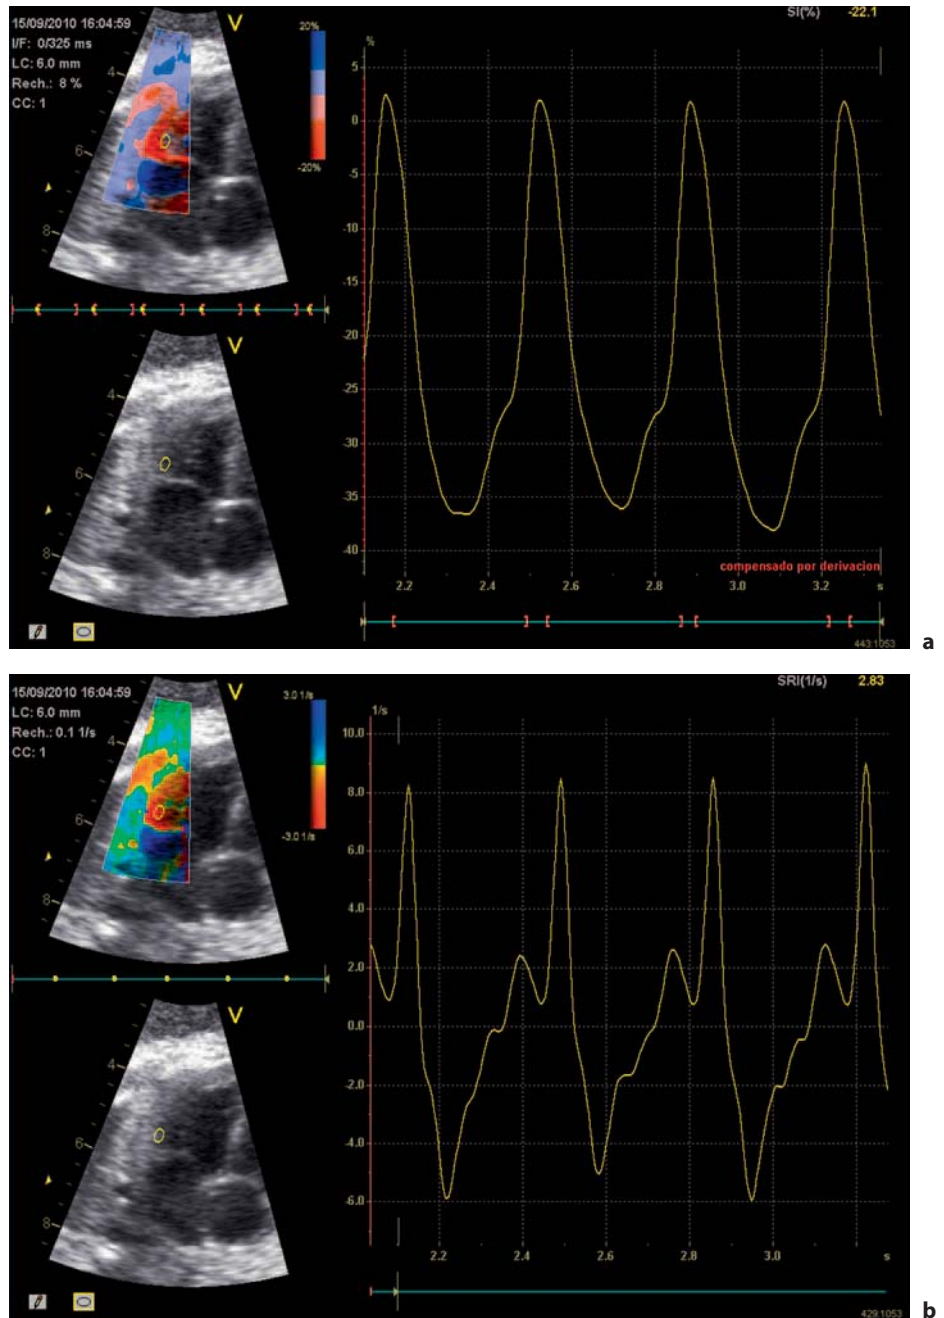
Tissue Doppler-derived strain (a) and strain rate (b) waveforms.
